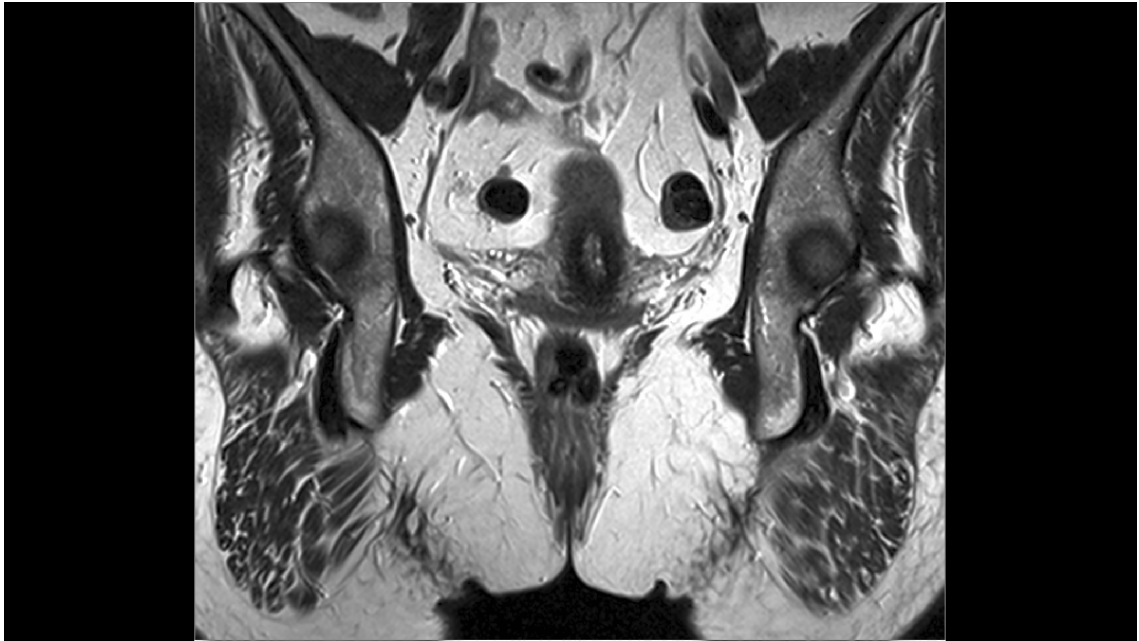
Coronal T2-weighted spin echo images of the anal canal demonstrating a) normal anatomy or grade 1 atrophy b) moderate or grade 2 atrophy c) severe or grade 3 atrophy of the external anal sphincter and puborectalis muscles.
